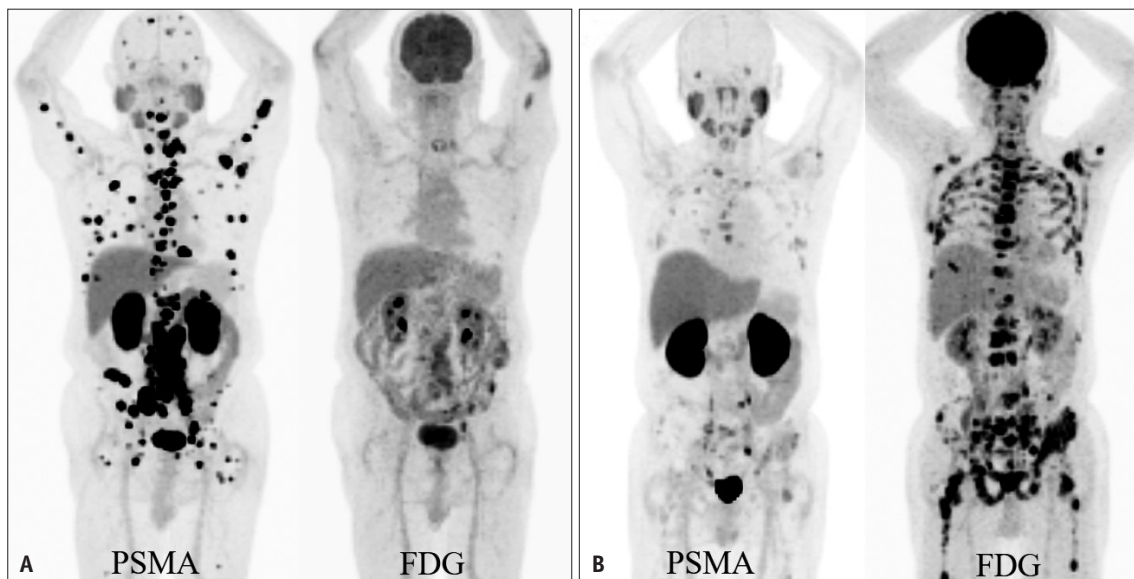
Representative PSMA and FDG discordant cases. A: A 75-year-old prostate cancer patient with PSA 94 ng/mL shows multiple sites of positive uptakes in abdominopelvic lymph nodes and bones on both PSMA and FDG PET/CT images. The tumor volume was greater in PSMA PET/CT. The disease duration was 51 months, LDH 180 U/L and AST 20 U/L. B: A 59-year-old prostate cancer patient with PSA 106 ng/mL is positive on both PSMA and FDG PET/CT, but shows FDG-dominant tumor volume. Multiple bone lesions show low uptake on PSMA PET/CT. Intense uptake is noted in the pelvic lymph nodes, bones and lung nodule on FDG PET/CT. The disease duration was 17 months, LDH 718 U/L and AST 51 U/L. PSMA = prostate-specific membrane antigen, FDG = [^{18}F]fluorodeoxyglucose, PSA = prostate-specific antigen, LDH = lactate dehydrogenase, AST = aspartate aminotransferase
